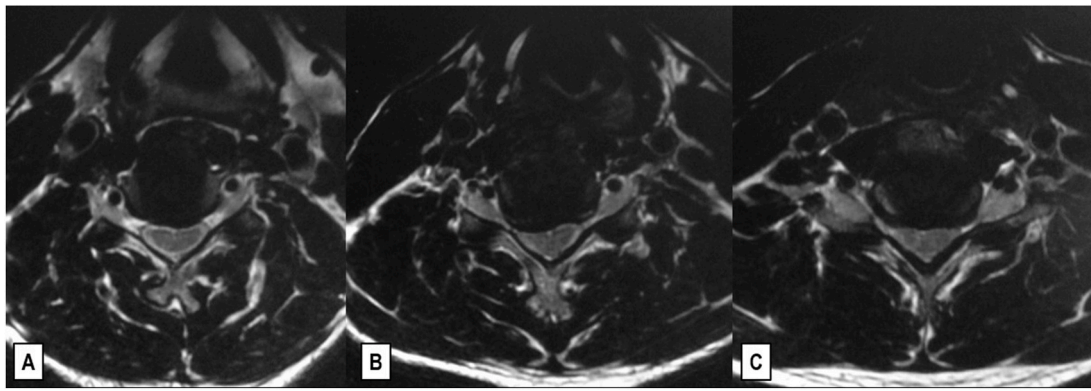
Radiographic MRI showed cervical spinal cord compression; Axial MRI T2-weighted images of cervical spine at C4/5 (A), C5/6 (B) and C6/7 (C) level.
